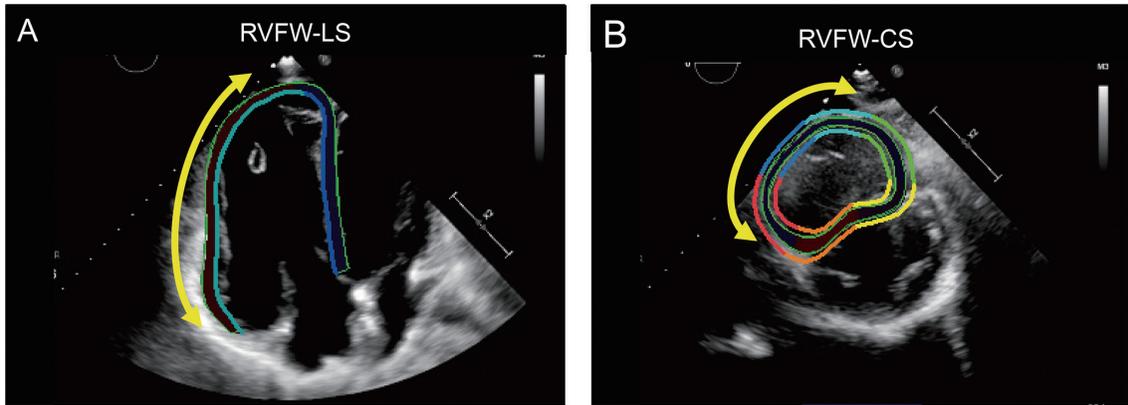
Representative images of two kinds of right ventricular systolic strain measured by two-dimensional speckle-tracking echocardiography (2D STE).
